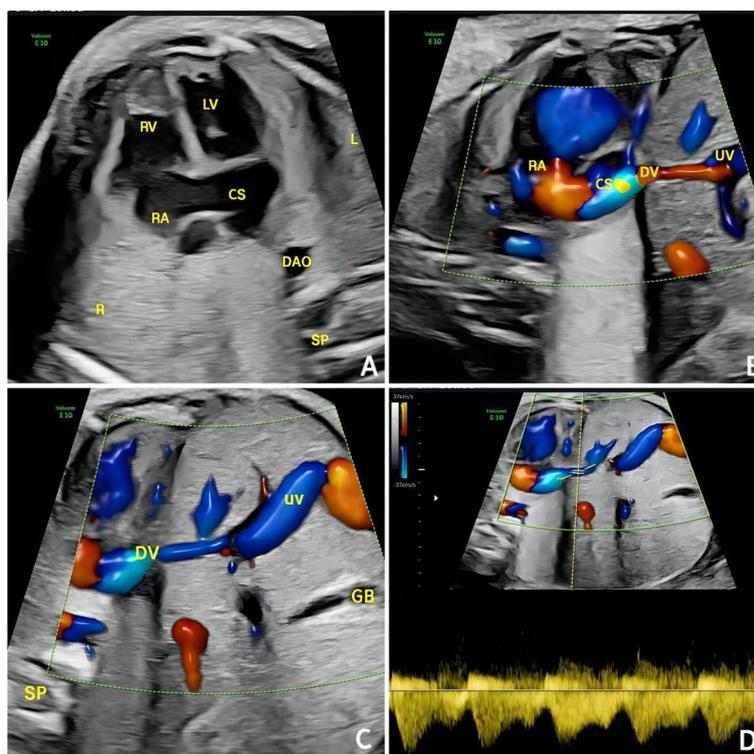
Two-Dimensional Ultrasound, Color Doppler, and Spectral Doppler Features of Anomalous Drainage of the Ductus Venosus into the Coronary Sinus. (1A) Sonograms reveal a dilated coronary sinus in the low four-chamber view. (1B) Parasagittal sonograms demonstrate the aberrant course of the ductus venosus (DV). Near the insertion of the inferior vena cava into the right atrium, an anomalous vessel is visualized draining into the coronary sinus. The vessel's connection to the umbilical vein (UV) confirms its identification as the ductus venosus (DV). (1C) Abdominal transverse sections show the abnormal trajectory of the ductus venosus from different angles. (1D) Pulsed Doppler flow at the ostium of the coronary sinus displays the characteristic ductus venosus waveform. RV: Right Ventricle; LV: Left Ventricle; RA: Right Atrium; CS: Coronary Sinus; DAO: Descending Aorta; SP: Spine; DV: Ductus Venosus; UV: Umbilical Vein; GB: Gall Bladder; L: Left; R: Right
